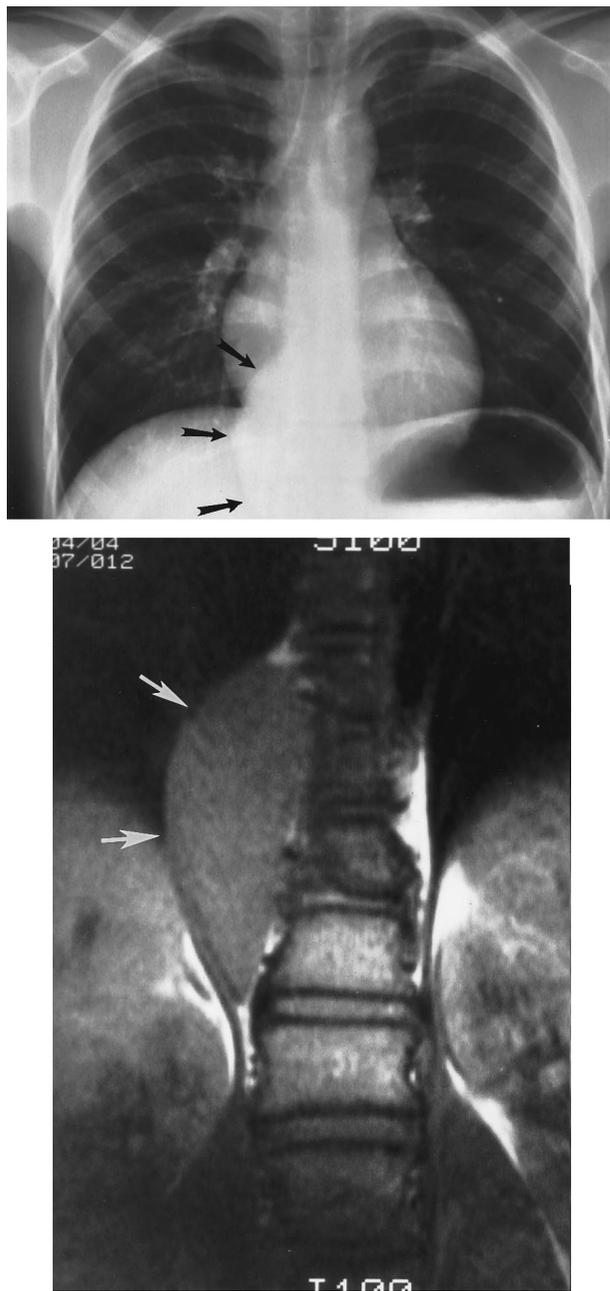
(Top) PA chest radiograph and (bottom) unenhanced T<sub>1</sub>-weighted coronal MRI in an asymptomatic 14-year-old male subject. A well-circumscribed, oblong posterior mediastinal ganglioneuroma (arrows) has homogeneous low- to intermediate-signal intensity without intraspinal extension.
